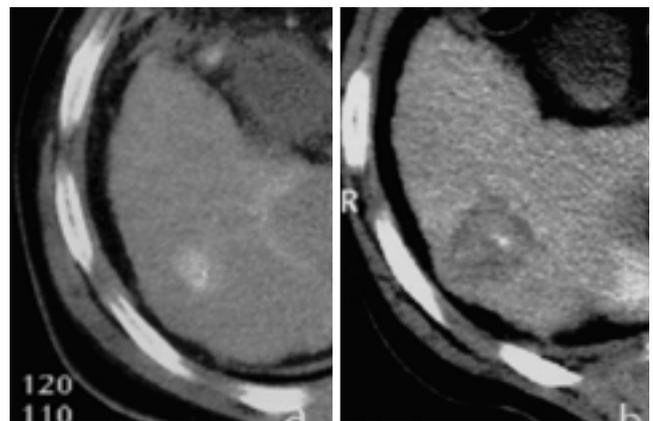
45 year-old man with hepatocellular carcinoma. A. In preoperative CT scan, well-enhanced nodular lesion in the segment VI of the liver. B. After RFTA, hypoattenuated ablated region was seen around mass, and extended more than 5 mm above the tumor margin, perfect ablated state.
